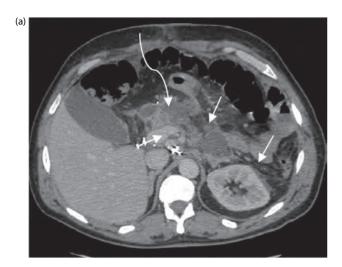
(a) CT scan of a 51 year old man following gastrectomy at the level of the pancreas. There is a multiloculated fluid collection around the pancreas (arrows). Note the tight safe window of drainage (curved arrow). (b) CT scan following insertion of two double-lumen pigtail drains under CT guidance. There is complete resolution of fluid collection.
